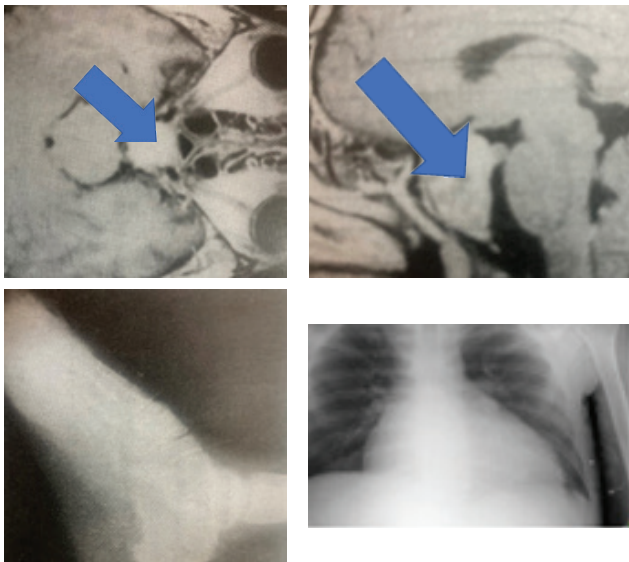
&2B: Arrow head in MRI brain showing pituitary macroadenoma, 2C: Xray heel - increase heel pad thickness 2D:Enlarged right and left ventricle
